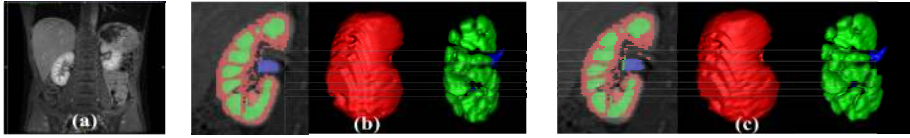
(a) An exemplar abdominal image from DCE-MRI data. 2D and 3D segmentation of inner compartments based on (b) manual label and (c) our method.
